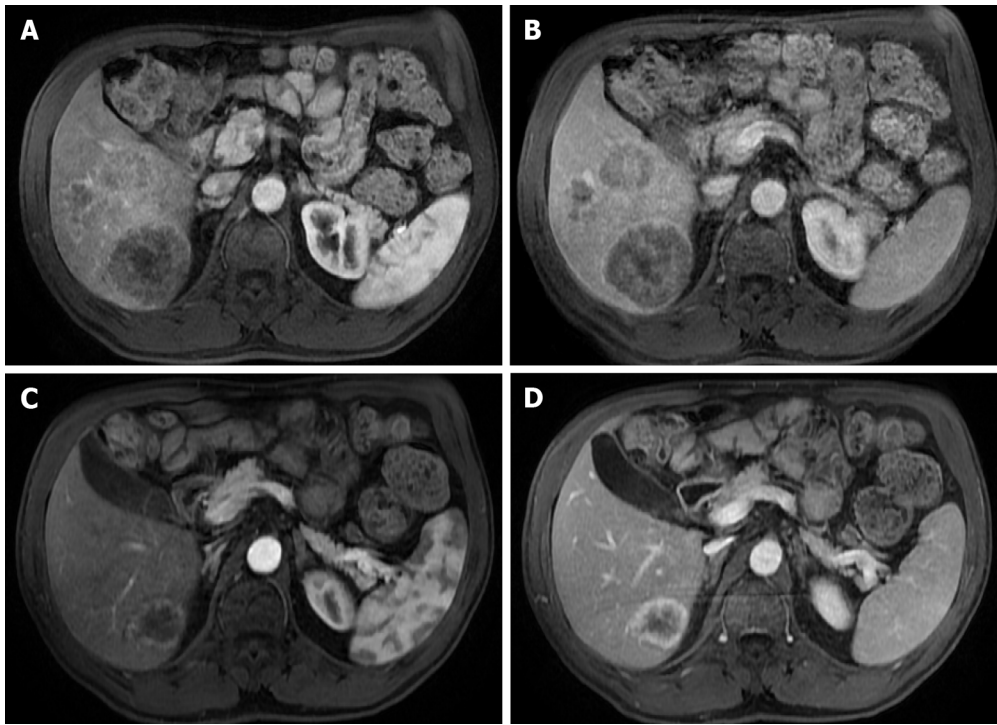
A 71-year-old man with unresectable CRLM. A and C: Axial fat saturated (FS) contrast-enhanced magnetic resonance imaging (CE-MRI) T1-weighted imaging (WI) in the arterial phase; B and D: Axial FS CE-MRI T1-WI in the portal-venous phase. Initial presentation of three heterogeneous hepatic lesions corresponding to unresectable CRLM before treatment (A and B). After chemotherapy (C and D), the patient presented partial response, with the disappearance of two lesions and reduced size of the larger lesion, which still presents viable peripheral tumor.
